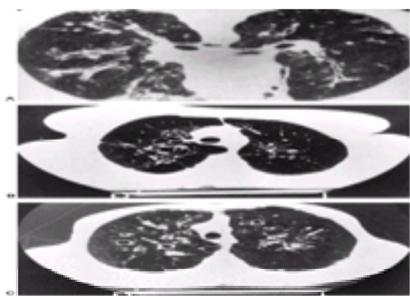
CT demonstrating cylindrical bronchiectasis with thickened bronchial walls (“tram lines”) in a patient with cystic fibrosis. B: Proximal varicose and cystic bronchiectasis in a patient with ABPA. C: Two examples of a “signet ring” sign. (Reproduced with permission from Hansell and Strickland. High-resolution computed tomography in pulmonary cystic fibrosis. *Br J Radiol* 1989;62:1–5.)
